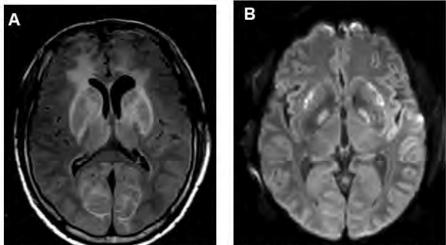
Immediate post-operative brain MR axial T2/FLAIR (A) and DWI (B) sequences demonstrate extensive T2/FLAIR hyperintense signal abnormality involving the bilateral basal ganglia, thalami, and occipital deep white matter with associated restricted diffusion in the bilateral basal ganglia. Additional bilateral frontal vasogenic edema was present on pre-operative brain MR exam related to patient's meningioma.
